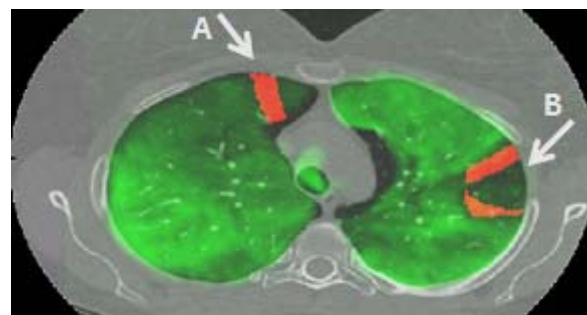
Fusion of co-registered images from baseline CT, post-exacerbation HP He MRI (green), and emergent ventilation defect mask (red). Ventilation defect A (RUL) is supplied by RB3; defect B (LUL) is supplied by LB2 and LB3. Note that defect B is emergent only on its periphery, indicating enlargement relative to baseline. HP He MRI acquired using gradient echo (GRE), 28 slices at 10mm thickness. Acquired in-plane axial resolution was 3.12mm x 3.12mm for HP He MRI (reconstructed at 1.56mm x 1.56mm).
